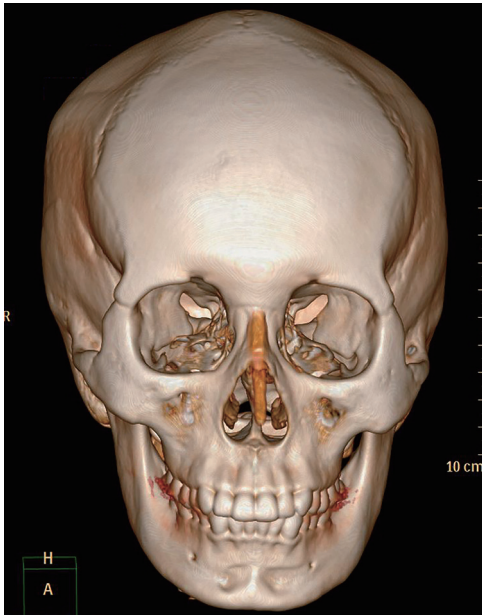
Additional case 4. Three-dimensional reconstruction of the computed tomographic scans from a 23-year-old woman. She could not remember the exact injection-related information. Evident bony resorption could be found in bilateral incisive fossa.
